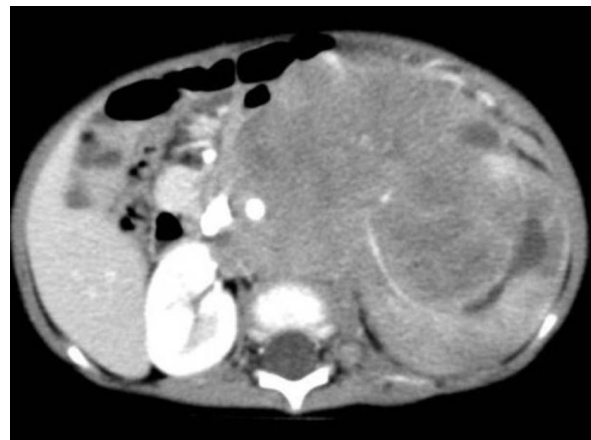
Neuroblastoma; Axial CT scans shows a large soft tissue mass, with areas of necrosis, crossing the midline and encasing and anteriorly displacing the aorta and inferior vena cava.
